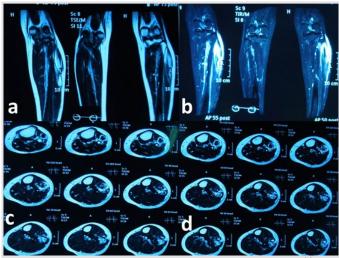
Pre-operative magnetic resonance imaging scan sagittal T2-weighted image (a), short tau inversion recovery image (b), and axial images (c and d) showing cystic lesion.
